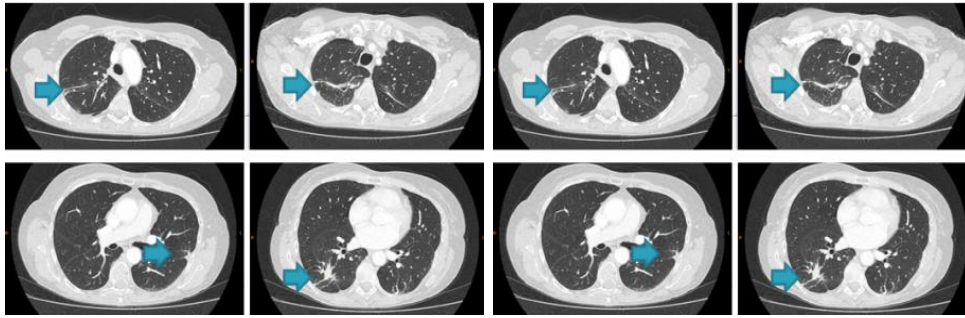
Chest computed tomography in axial planes after lung metastasectomy demonstrating no signs of metastatic recurrence; only fibrotic changes are visible
